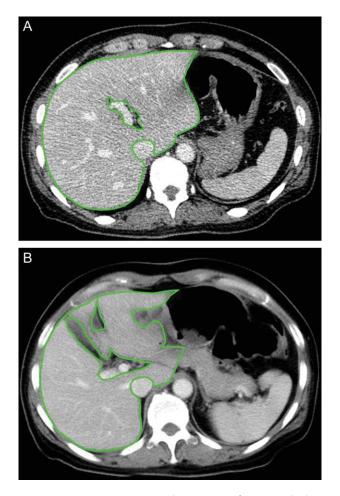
Liver contours on axial CT images after manual editing show the isolation of the liver from the surrounding structures. The inferior vena cava, the main trunk and bilateral first branches of the portal vein, and the major fissures are excluded from the liver region. The contours are drawn on (A) a 0.625-mm 3D image and (B) a 10-mm image. Partial volume effects are much more prominent on the 10-mm image versus the 0.625-mm image.
